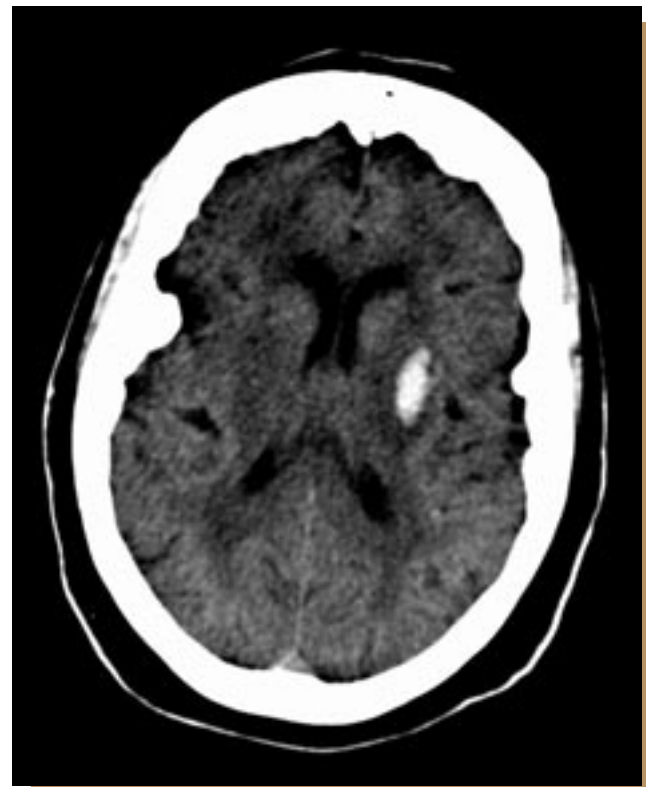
A noncontrast CT image of a different patient with malignant hypertension who developed an intraparenchymal hemorrhage in the left globus pallidus. Thrombolytic therapy would likely cause serious complications in this patient.
